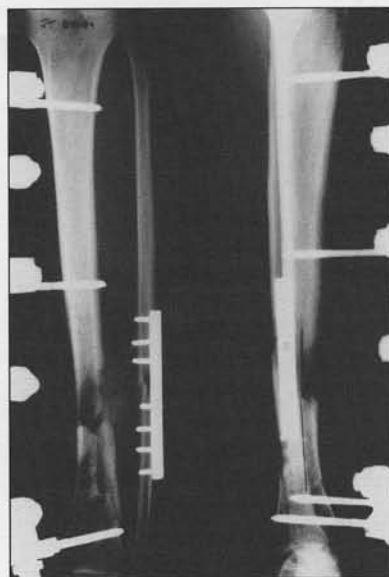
Radiographs of a grade IIIa comminuted open tibia-fibula fracture in a 22-year-old man. The anteroposterior (L) and lateral (R) views show the stabilization with an external fixator. The fibula has been plated to serve as a substrate for planned posterolateral bone graft.
